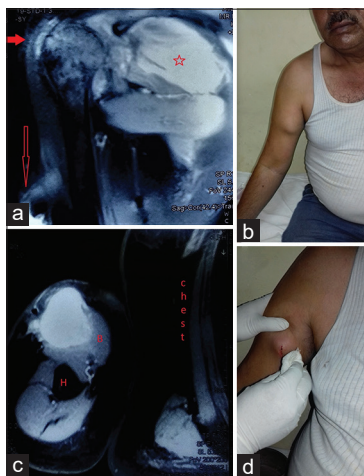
The MRI image showing collection within the scapular muscle (infraspinatus, denoted by star) and teres minor below (a) Associated shoulder joint infective arthritis with periarticular edema (denoted by short arrow) and joint destruction is also noted. The clinical image showing associated nodular swelling over ipsilateral biceps muscle in the mid-arm region (b) The MRI showed corresponding localised swelling in the mid-arm (denoted by long arrow) suggestive of a collection within the biceps muscle (c) The collection is probably a cold abscess within the biceps brachii muscle (denoted by B, humerus is H). The biceps swelling was aspirated for further investigations (d)
